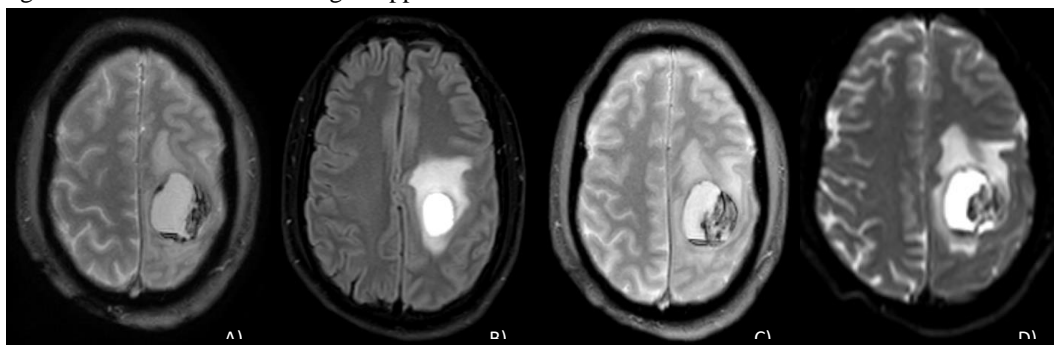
Brain Contrast enhanced MRI: intra-axial lesions, oval, circumscribed at the level of the left precentral gyrus and ipsilateral lingual gyrus, and large cystic portions which show fluid-liquid levels, without diffusion restriction after the administration of intravenous contrast with avid ring enhancement as well as the mural nodules, the largest measuring 44.5 x 41.8 x 36.0 mm. Vasogenic edema that causes compression of the left lateral ventricle and ipsilateral atrium as well as deviation of the midline of up to 4.4 mm. Intra-axial lesions in the left frontal and occipital lobes, highly suggestive brain metastases. A) T1 Weighted Gadolinium enhanced. B) T2/Flair Weighted Gadolinium enhanced. C) Gradient Echo sequence. D) Diffusion Weighted Imaging.
